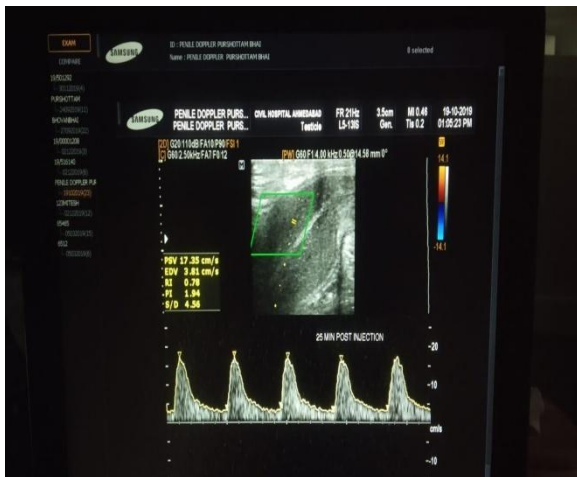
Doppler showing arterial insufficiency with decreased peak velocity
